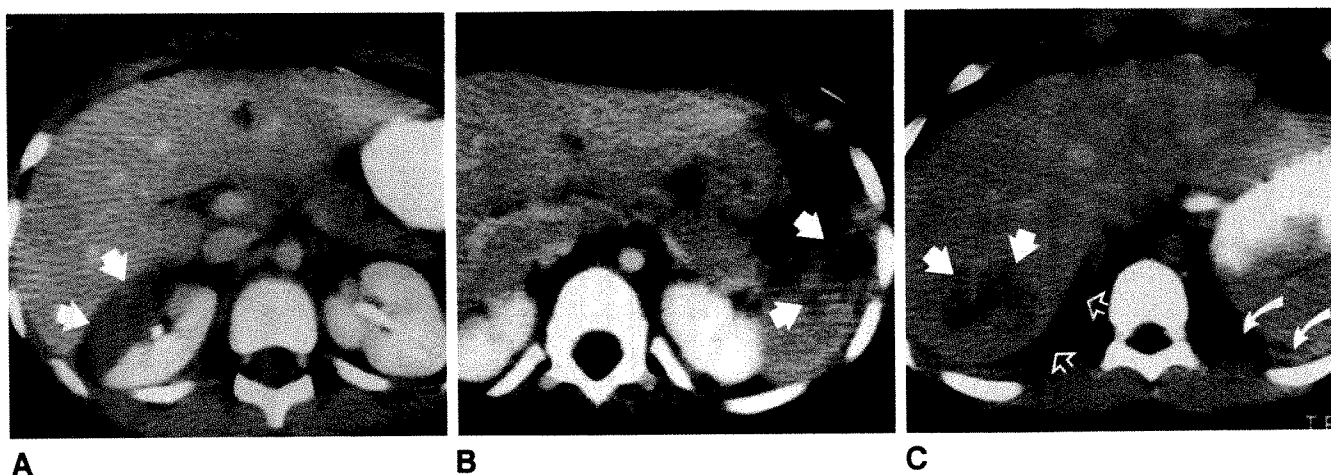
Parenchymal trauma shown on conventional CT scans. Technicare 2020HP, 2-sec scanning with 3 ml/kg bolus contrast material. All injuries were sustained in motor-vehicle accidents.
